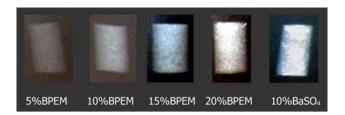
Radiographs for acrylic bone cements modified with BPEM versus acrylic bone cement with $BaSO_4$
